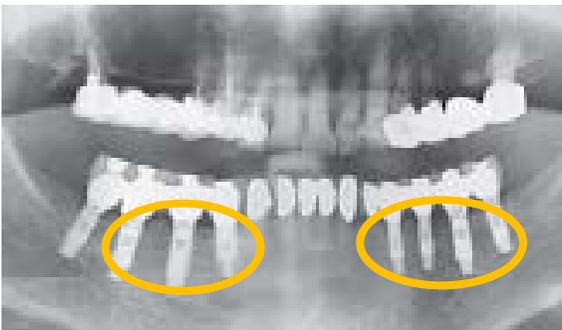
Post-operative radiograph after ridge augmentation with TruForm and placement of multiple dental implants.
